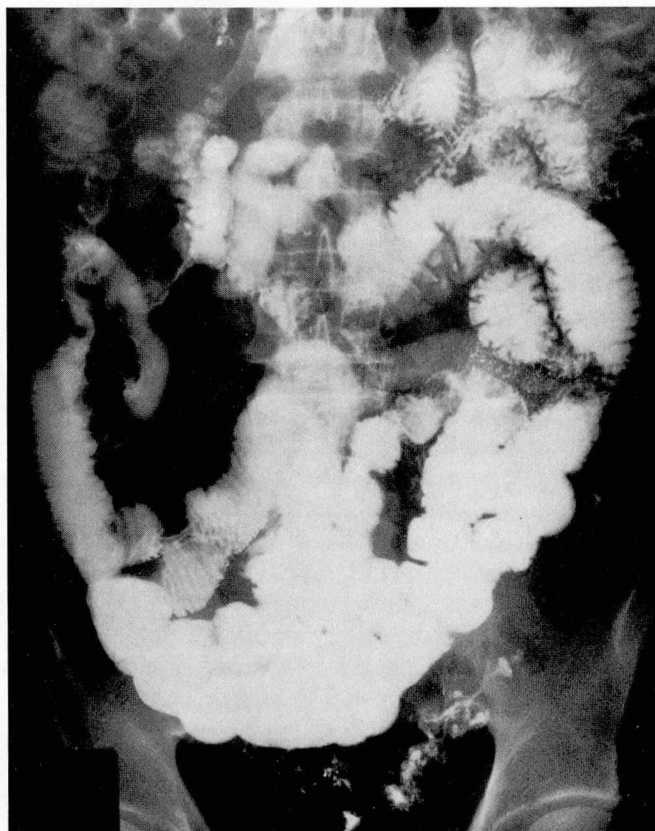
Case 4. Radiograph from small bowel series showing multiple narrowed, irregular areas of the terminal ileum and mild prestenotic dilatation.
